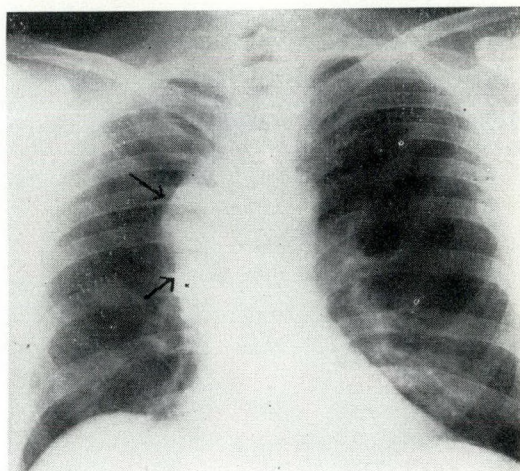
Radiograph showing collapsed right upper lobe of lung (see arrows).
